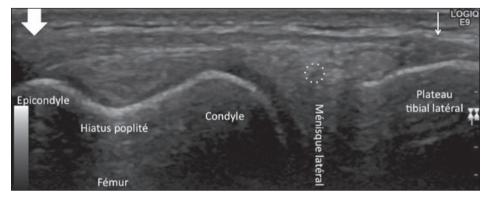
Ultrasound of the ALL. Study with a high frequency 12 MHz superficial transducer. Normal appearance in resting position in a longitudinal section. The ligament is thicker at its femoral enthesis (large arrow) and thinner at its tibial enthesis (small arrow). It crosses the lateral inferior genicular artery (dotted circle).
